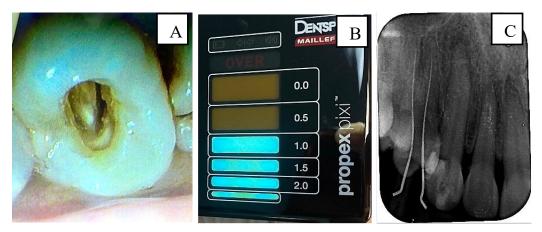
(a) Tooth 14 after pulp tissue removal, (b) *Electronic apex locator*, (c) Periapical radiograph determining IAF with PK 21 mm on the buccal and palatal
